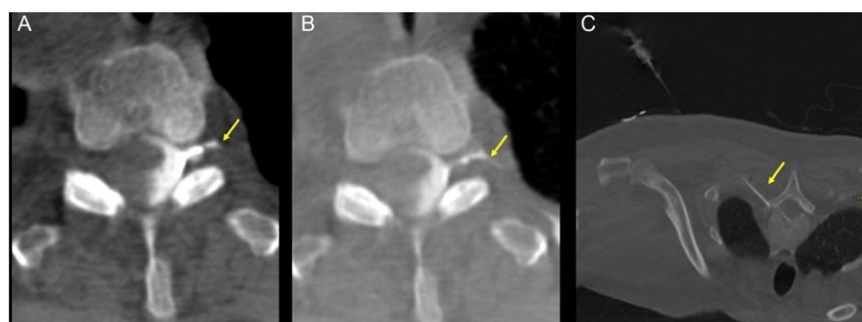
CT myelogram of the patient. CT myelogram demonstrating (A) early contrast leakage and (B) delayed (5 minutes) contrast extension from the nerve root sleeve into an adjacent paraspinal vein at the left T2-3 foramen (yellow arrows). (C) Transforaminal epidural injection of fibrin glue at the left T2-3 level via a left transforaminal approach (yellow arrow).
